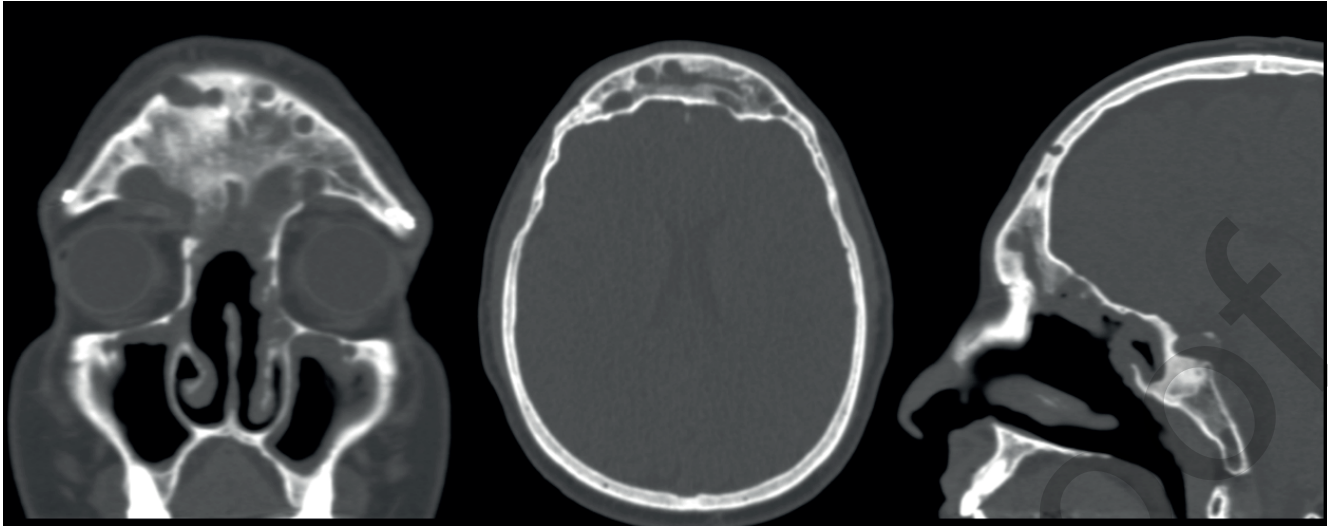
CT aspect of chronic osteitis of the frontal bone. Note the diffuse thickening with ground glass appearance, sparse mucocoeles and areas of bony erosion.
